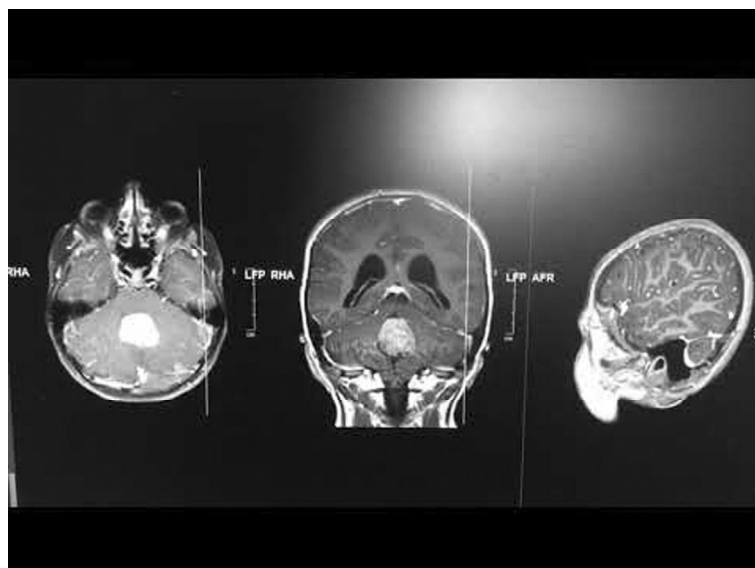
MRI scan 10 days after the start of treatment with cellex
